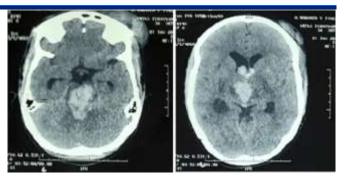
Transverse section cerebral CT scan showing a massive cerebro-meningeal hemorrhage with a mesencephalic and pontine hematoma.
